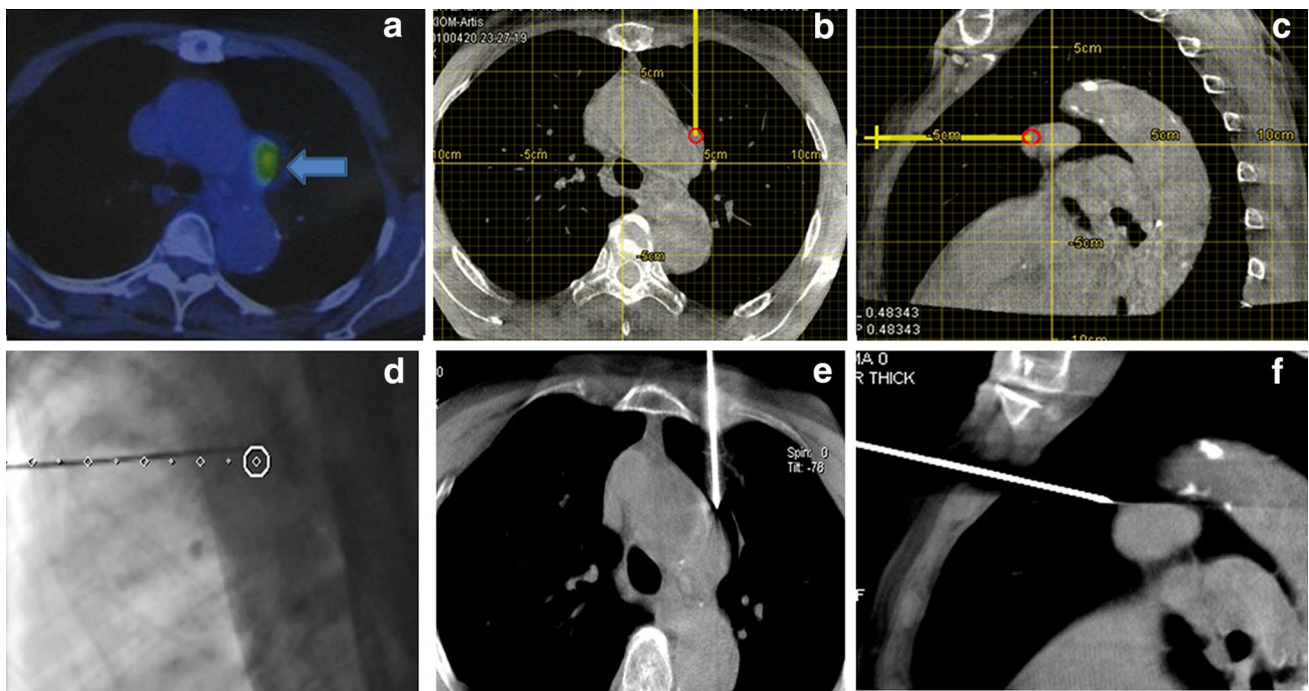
80-year-old patient, preoperative PET-CT showed a 1.8 cm lesion in middle mediastinum (a). CBCT orthogonal multiplanar images with graphics showing planned needle path (yellow line) into
